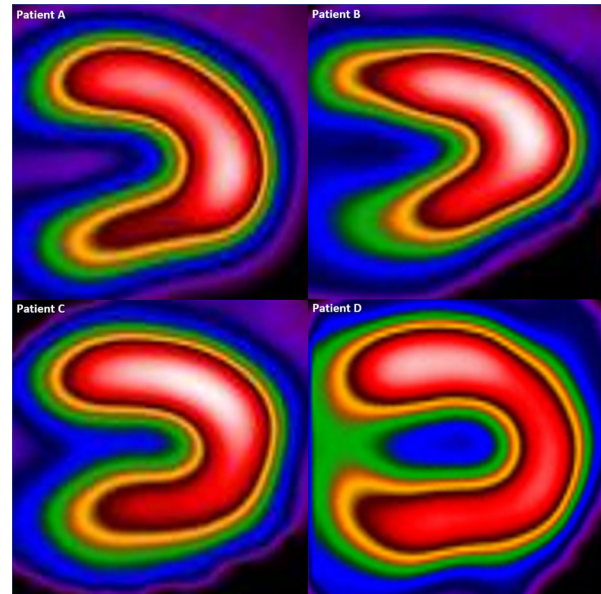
Stress-only myocardial perfusion imaging with single photon emission computed tomography using cadmium–zinc–telluride technology for the same patients described in Figure 1, all showing normal perfusion..
